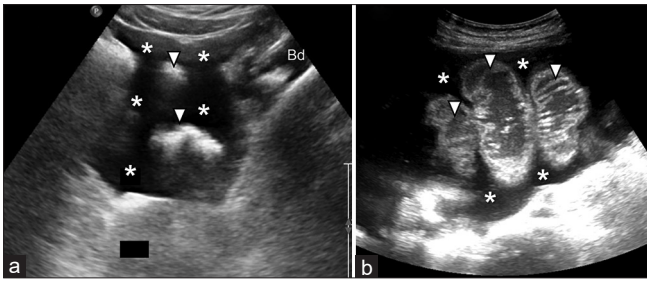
Positive FAST pelvis views of different patients (a: sagittal plane and b: axial plane). It is possible to see large amounts of peritoneal fluid (white asterisks), assumed to be blood in the trauma context, around bowel loops (white arrowheads). In A, the bladder is partially full (Bd). Bd: Bladder, FAST: Focused assessment with sonography for trauma
